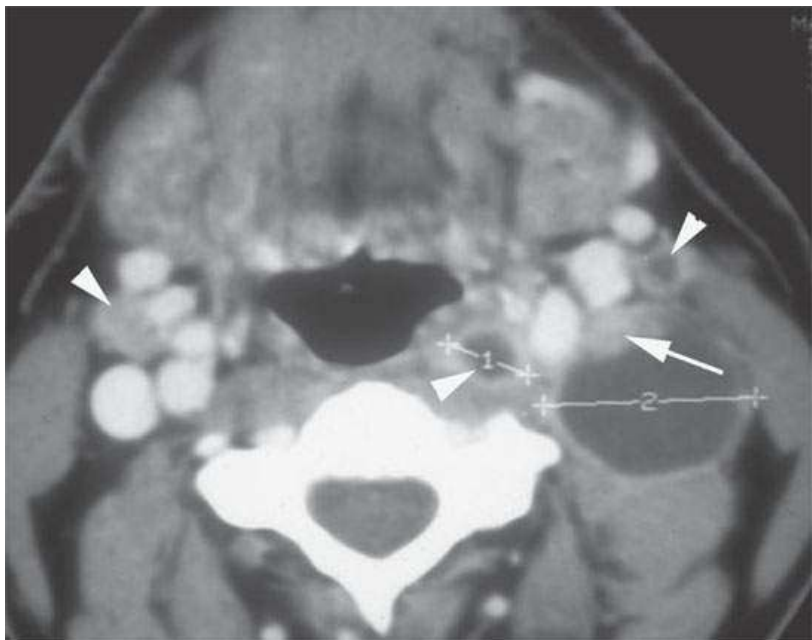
Contrast-enhanced computed tomography of a relatively thin walled level 2 mass. The mural nodules and other metastatic nodes (*arrowheads*) become a clue to the etiology. In contrast to inflammatory collections, there is little if any reactive change or edema around the largest of the metastatic nodes.
